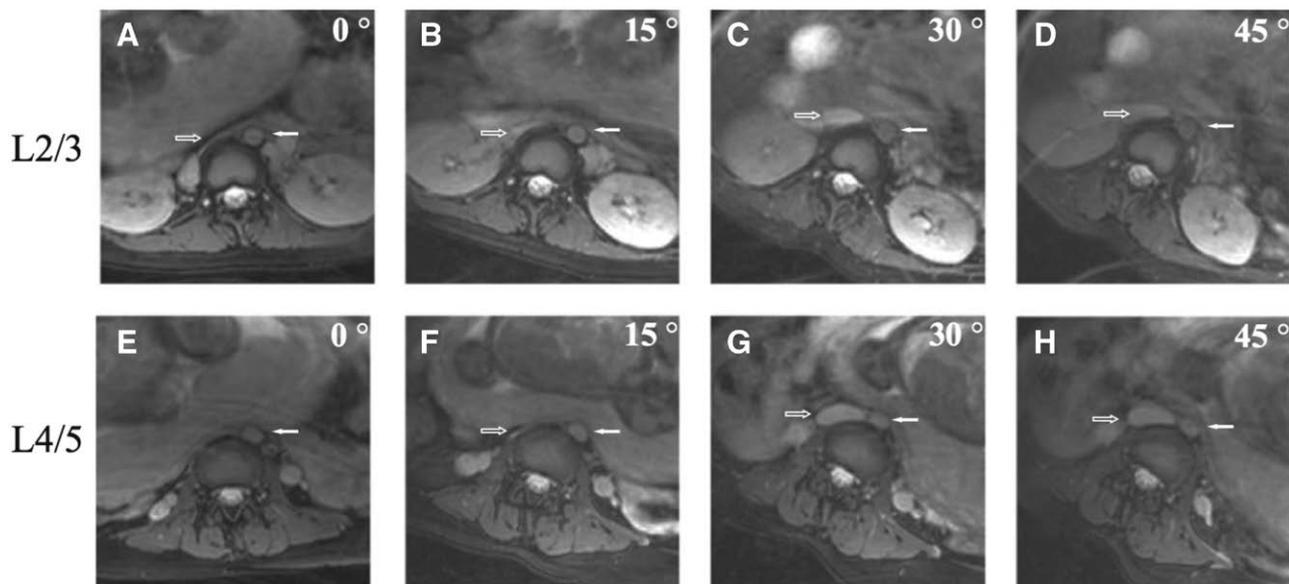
Magnetic resonance images of a 42-year-old pregnant woman (the fetus was in the right occiput position) in either the supine position (A and E) or at 15° (B and F), 30° (C and G), or 45° (D and H) left tilt positions at the L2-3 disk level (A–D) and the L4-5 disk level (E–H). Aortic size (solid arrow) did not change significantly in any position. The inferior vena cava (IVC; outlined arrow) was almost completely compressed, and the shape appeared band-like in the supine position. In the 15° left tilt position, the fetus was moved slightly to the left, slightly reducing IVC compression. IVC compression was significantly reduced in the 30° left tilt position. The IVC was not identifiable in the supine position. In the 30° and 45° left tilt positions, IVC compression was significantly reduced. The abdominal aorta did not divide to the common iliac artery at this level. The aorta was slightly deformed in the 15°, 30°, and 45° left tilt positions. In these axial images, anterior is at the top of the figure, and anatomic right is to the left in the figure. Used with permission from Higuchi et al.²⁰
